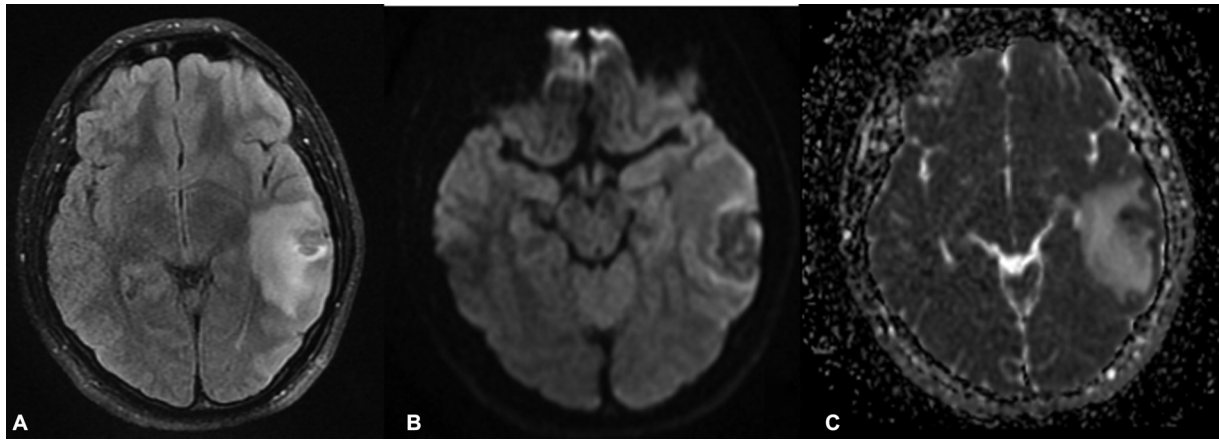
Axial MRI FLAIR (A) demonstrates a large area of FLAIR hyperintensity, DWI hypointensity (B), and ADC hyperintensity (C) involving the left posterior temporal region, representing edema with mass effect.
